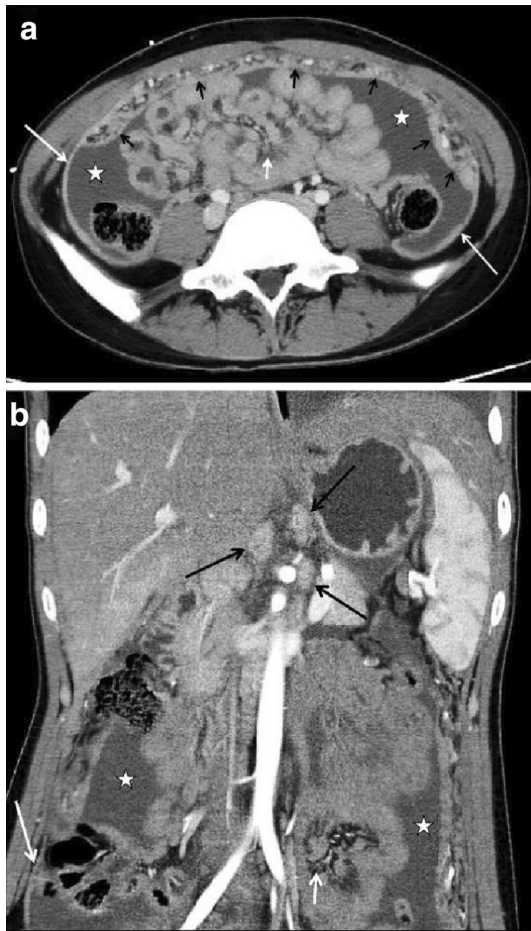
Axial and coronal CT section through the abdomen in the venous phase in a 20-year-old woman with PTB. a, b Smooth thickening of the peritoneum (long white arrow), thickened with crowded vascular bundles of the mesentery (short white arrow), OR sign (short black arrow) and high-density ascites (star)
